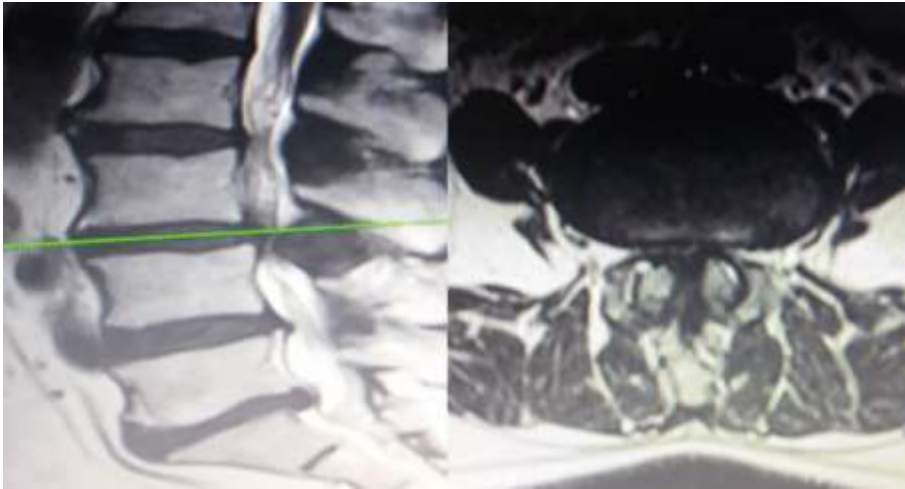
Sagittal and axial view of L3-4 spinal stenosis on MRI
